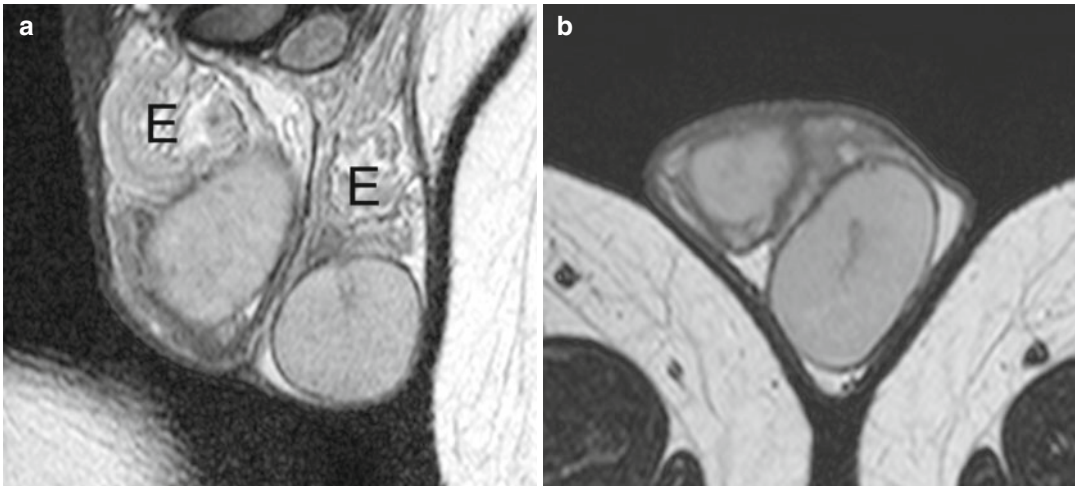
Surgically proved bell-clapper deformity. The patient had several episodes of acute scrotal pain on both sides which released spontaneously, interpreted as recurrent episodes of low-degree torsion with spontaneous detorsion. Coronal (a) and axial (b) T2-weighted images
